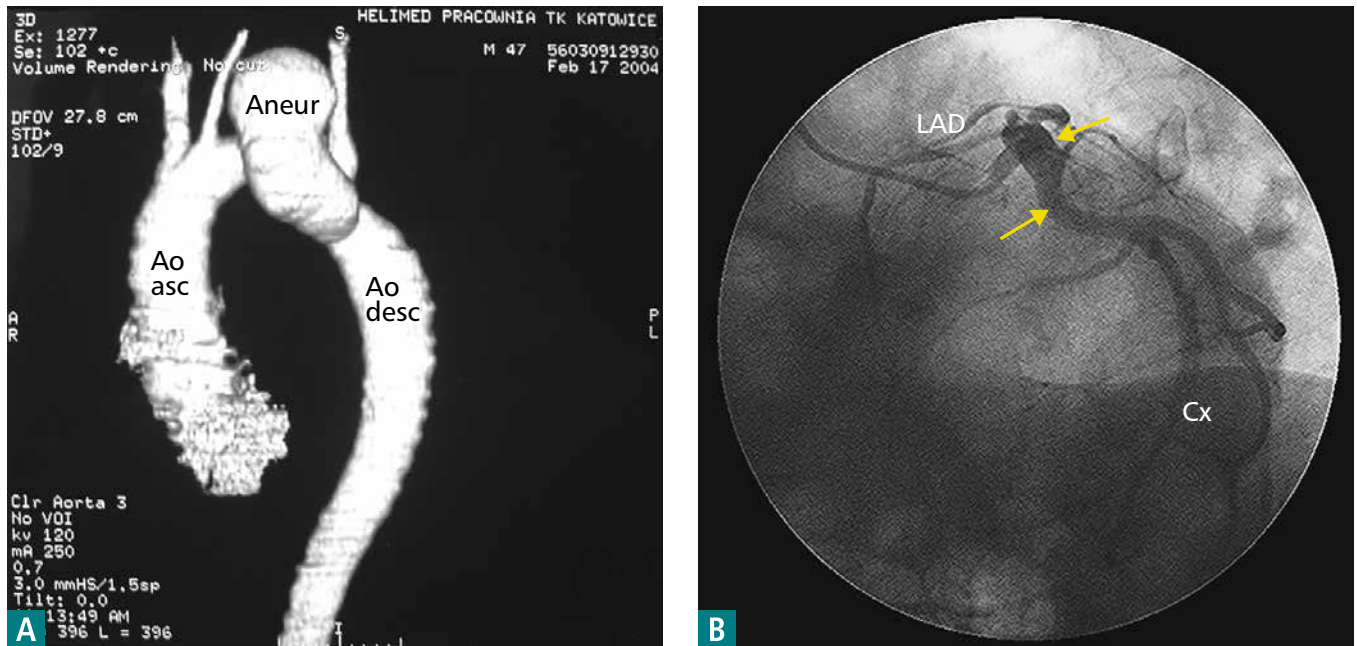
Panel A. 3D magnetic resonance imaging reconstruction of the thoracic aorta, presence of an aortic arch aneurysm. Panel B. Coronarography, aneurysmatic dilatation of the left main coronary artery and of the proximal segment of the circumflex coronary artery (yellow arrows). Ao asc – ascending aorta, Ao desc – descending aorta, LAD – left anterior descending artery, Cx – circumflex artery
